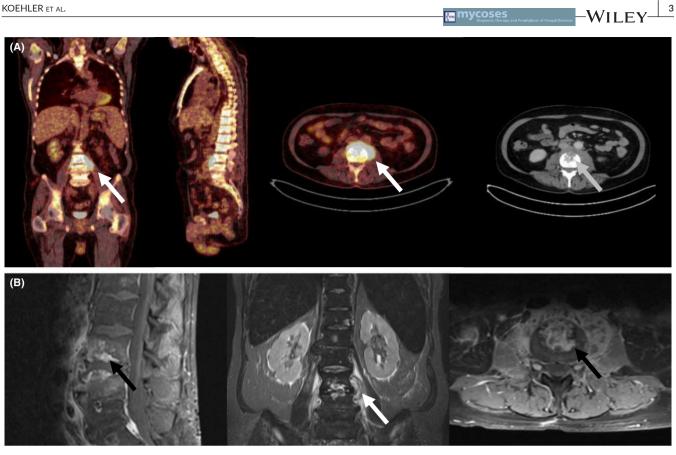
Imaging studies of Candida spondylodiscitis and paravertebral abscess. (A) Positron emission tomography computer tomography with [¹⁸F] 2-fluoro-desoxy-D-glucose (FDG-PET/CT) shows pathological FDG uptake in the I3-I4 vertebrae including the left psoas muscle (white arrows), as well as bone destruction (grey arrow). (B) From left to right: sagittal, coronal and axial magnetic resonance imaging (MRI) of the lumbar spine revealed abnormal signal/enhancement of the L3-4 vertebral marrow (black arrow) including intervertebral space and paraspinal soft tissues (white arrow) indicative for spondylodiscitis and adjacent psoas abscess
